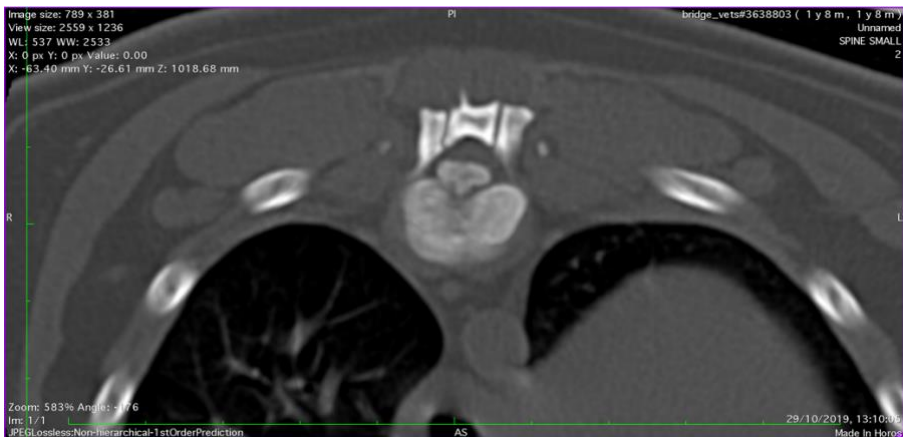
CT 3D MPR Trv T11/12
